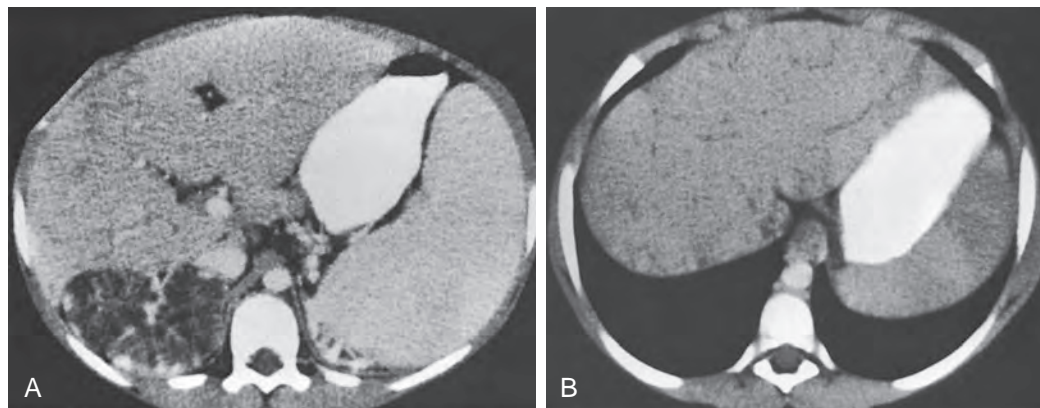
Autosomal dominant polycystic kidney disease. A. CT scan through the upper abdomen reveals multiple, small renal cysts. B. Numerous, small liver cysts are seen better on a higher section.
